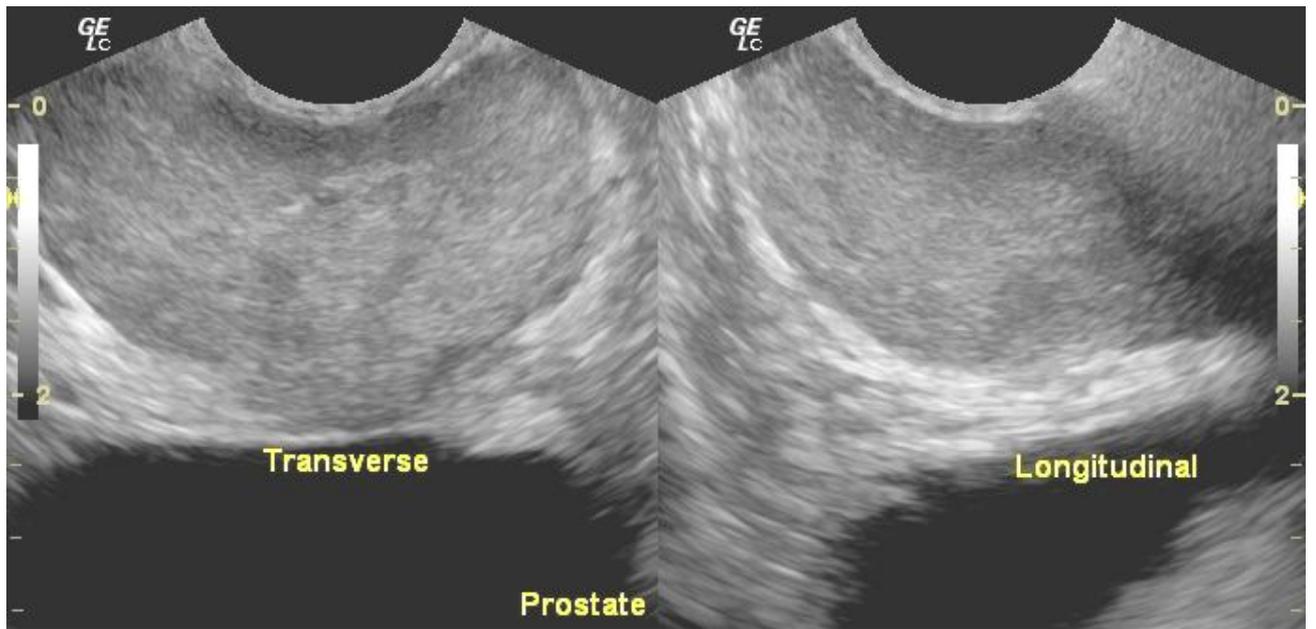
Image of ultrasound scanning of the normal prostate
